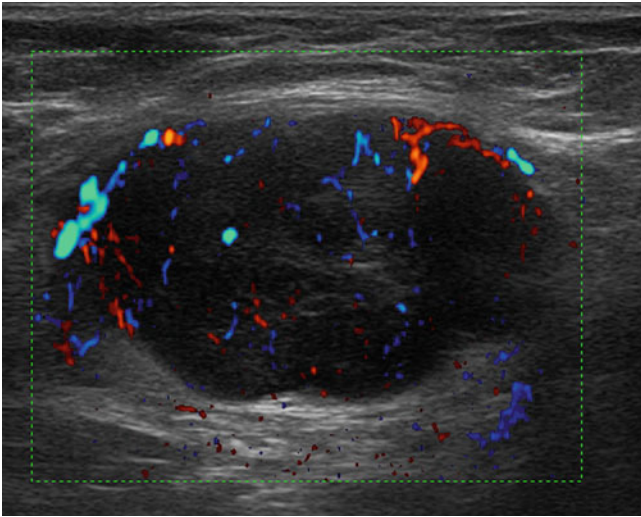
Metastatic lymph node. Large, metastatic lymph node of the axilla showing diffuse and anarchic vascularization at directional power Doppler imaging
